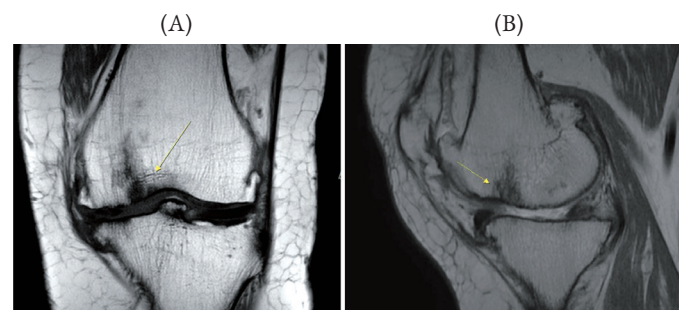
Magnetic resonance imaging scans (January 8, 2019). (A) Coronal T1-weighted image and sagittal proton density-weighted image. (B) Spontaneous osteonecrosis of the knee in the lateral aspect of the medial femoral condyle.
